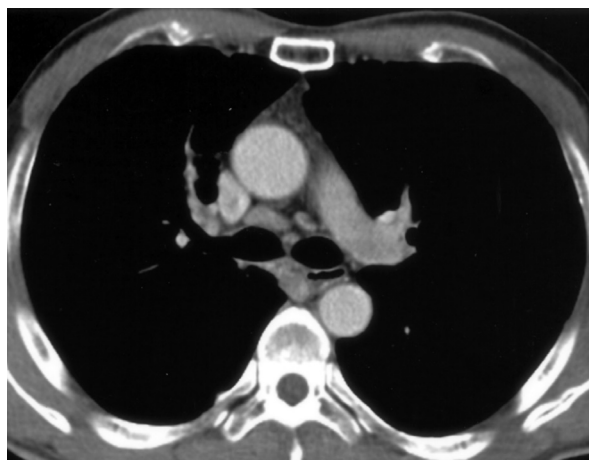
Chest CT with a mediastinal window view shows enlarged lymph nodes in the mediastinum.
